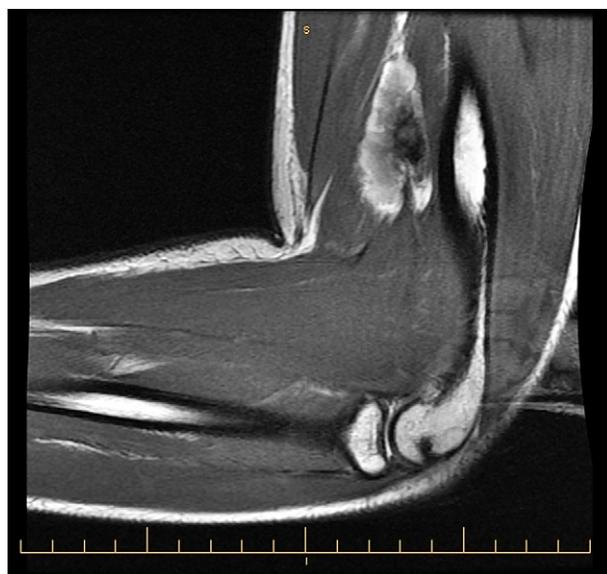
A sagittal section magnetic resonance image of the elbow shows a hematoma in the brachialis muscle belly.
